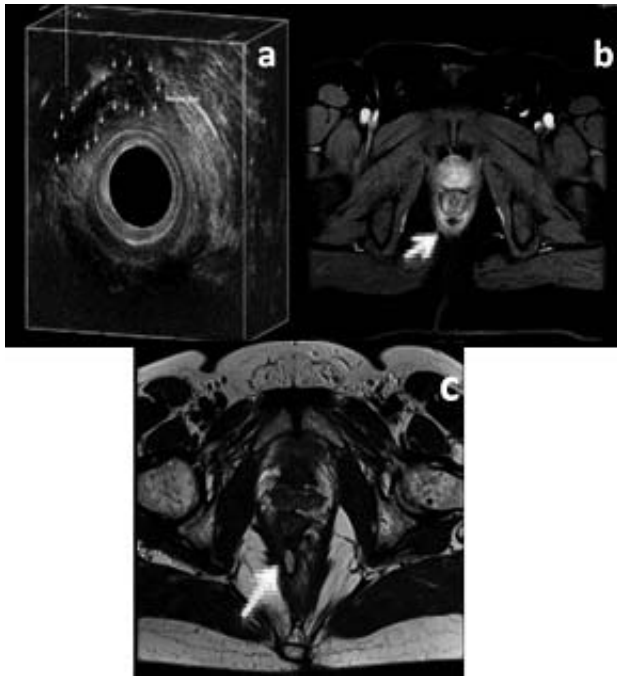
EAUS (a) and MRI (b, c) views showing (arrows) the ACDs.
